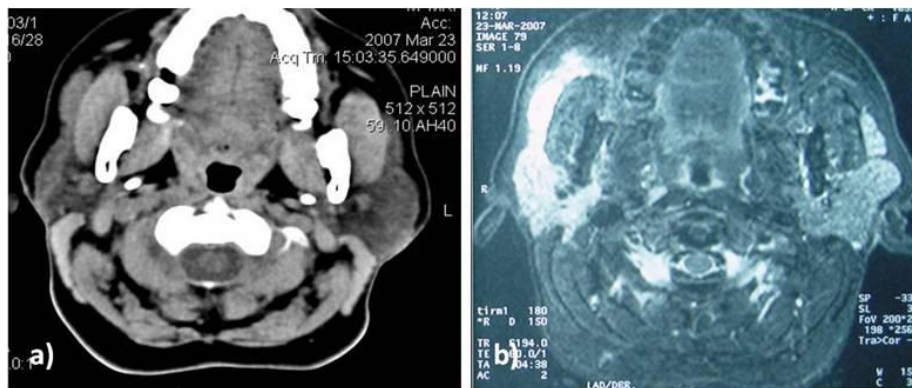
4 a) CT scan showed a small calculus in the right parotid duct in its terminal part. b) MRI revealed dilatation of right Stensen's duct and secondary ducts within the right parotid gland.
